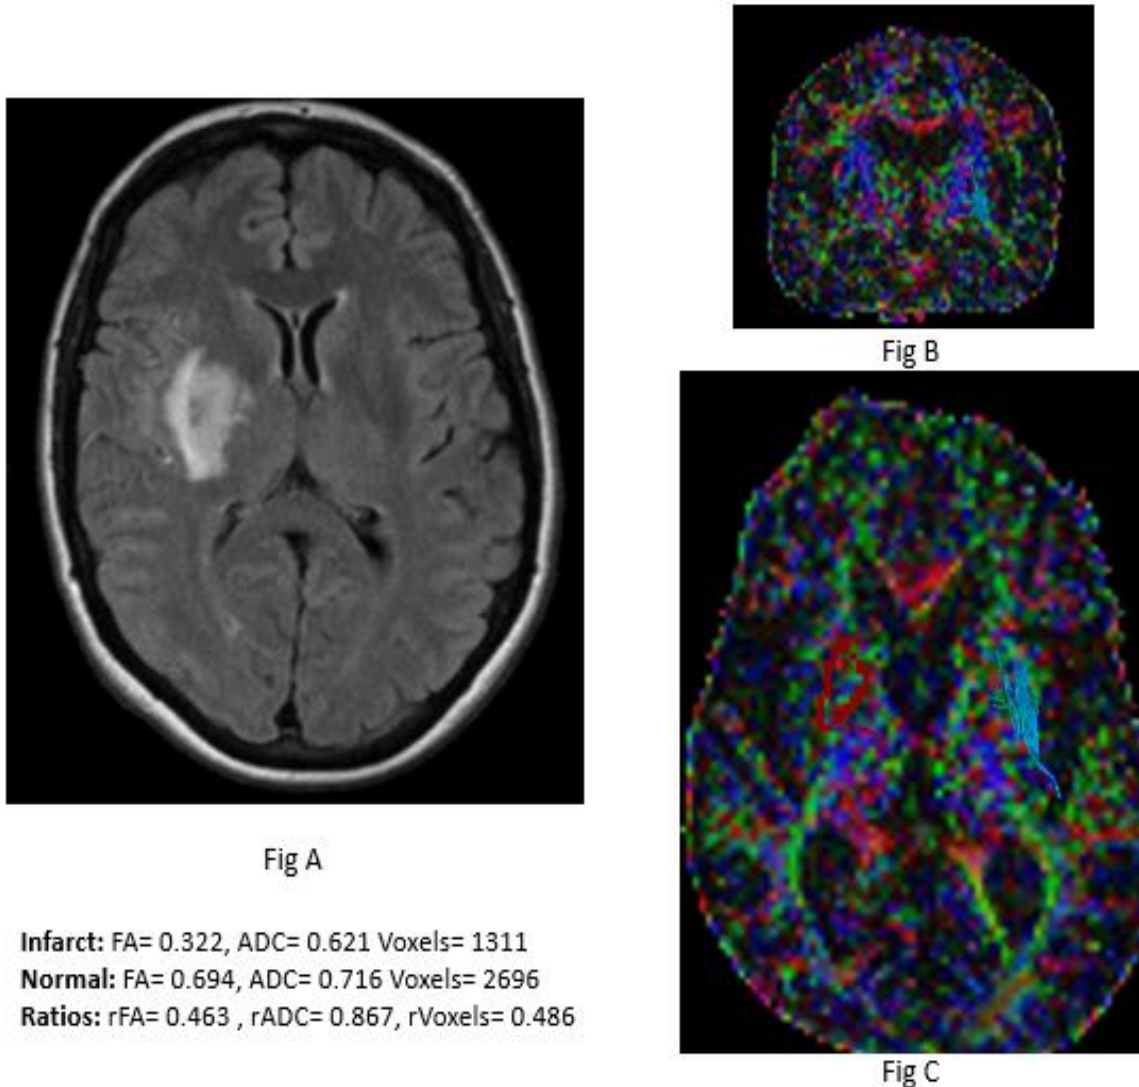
FLAIR axial image shows hyperintensity in the right capsuloganglionic region.
